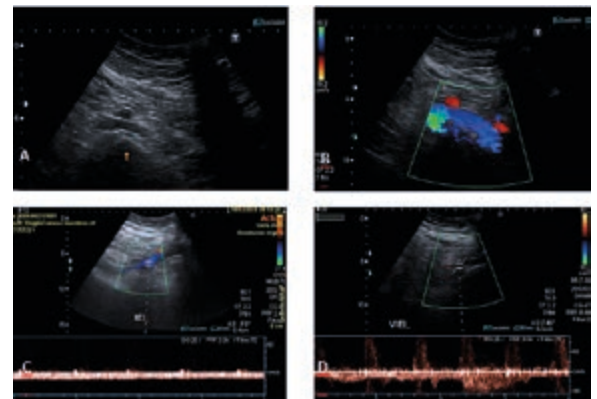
A and B) Postoperative management of a patient with MTS (Figure 4). Note the stent inside the left primitive iliac vein (patent). C) Previous spectral Doppler of left external iliac vein with flattened spectral pattern with loss of phasicity, an indirect sign of MTS. D) Spectral Doppler of left external iliac vein post-PTA that recovers phasicity when proximal compression is resolved.
